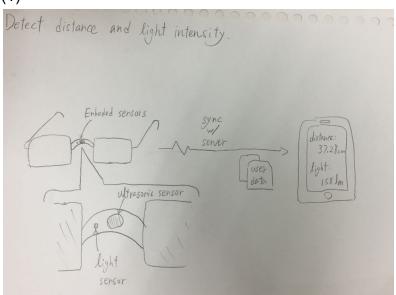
In order to satisfy task 1 of detecting distance and light intensity, embedded sensors on the glasses use ultrasonic sensor and light sensor to detect and send data to the phone.
